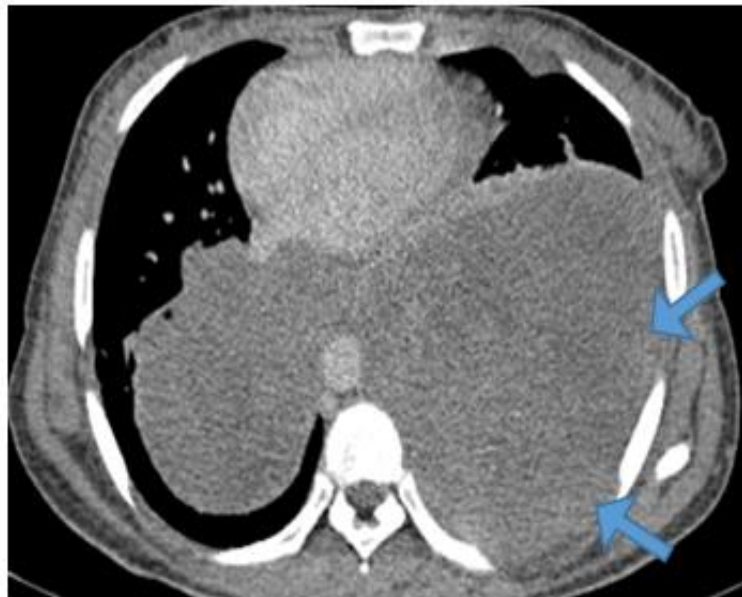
CT Scan showing an extensive pleural mass with compressive atelectasis of the underlying lung and with invasion of the intercostal spaces.
